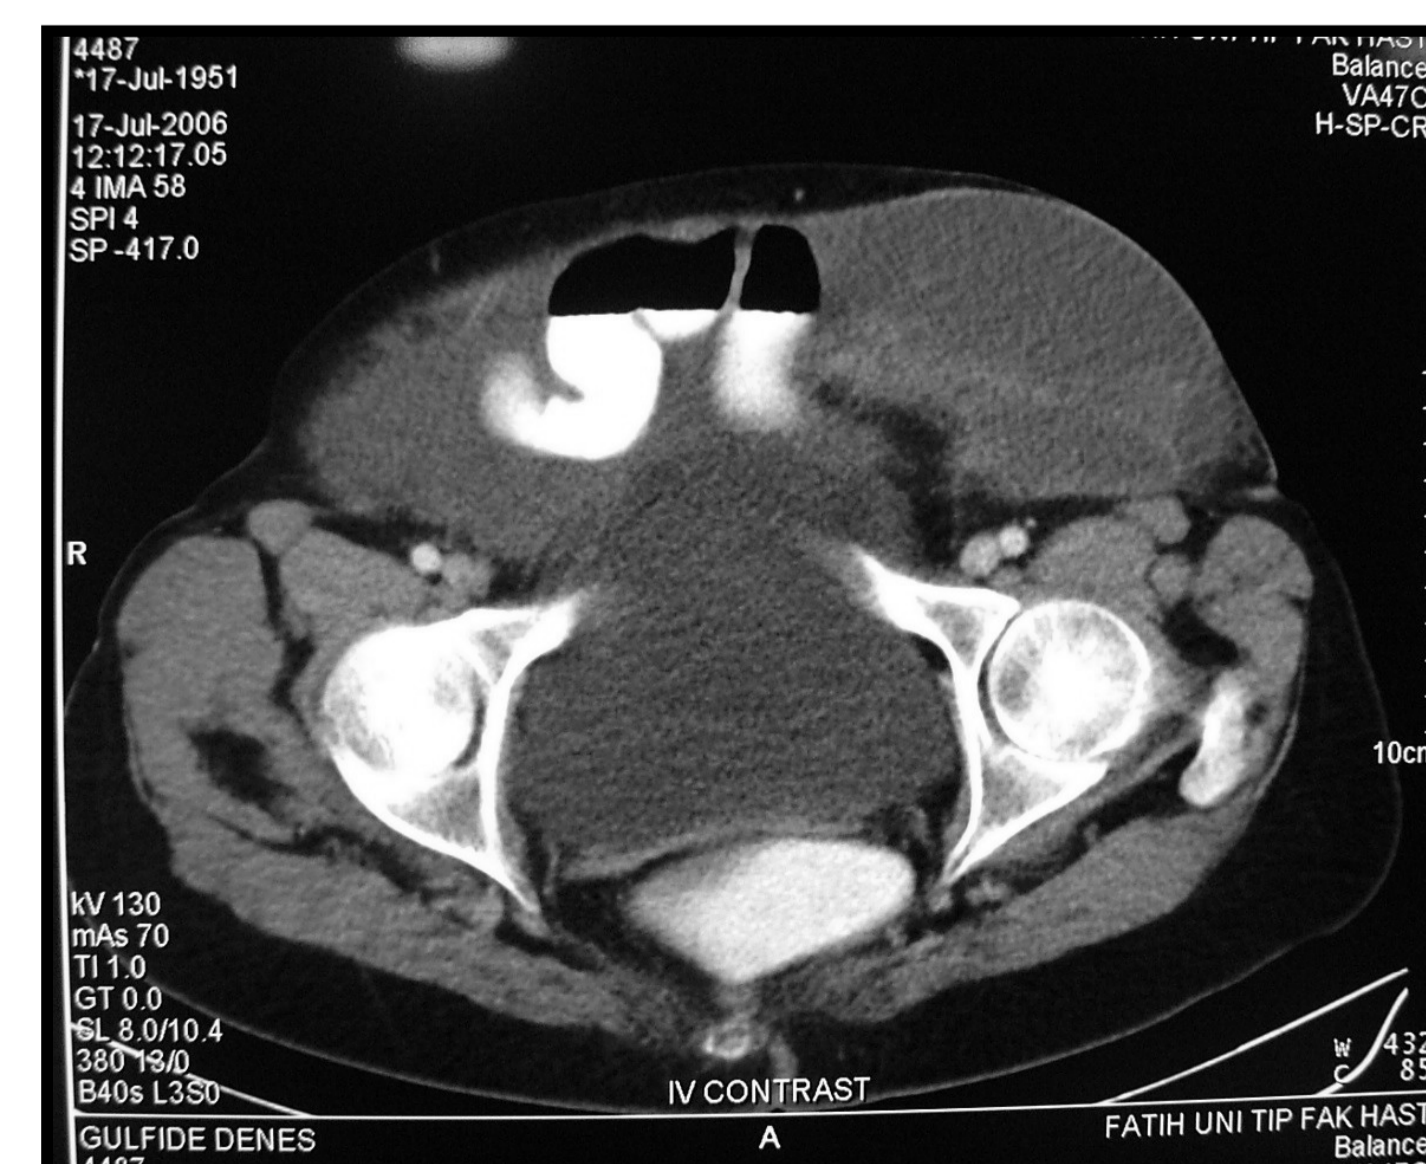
Magnetic resonance imaging of the case. A large incisional hernia containing bowel loops and a great amount of fluid.
